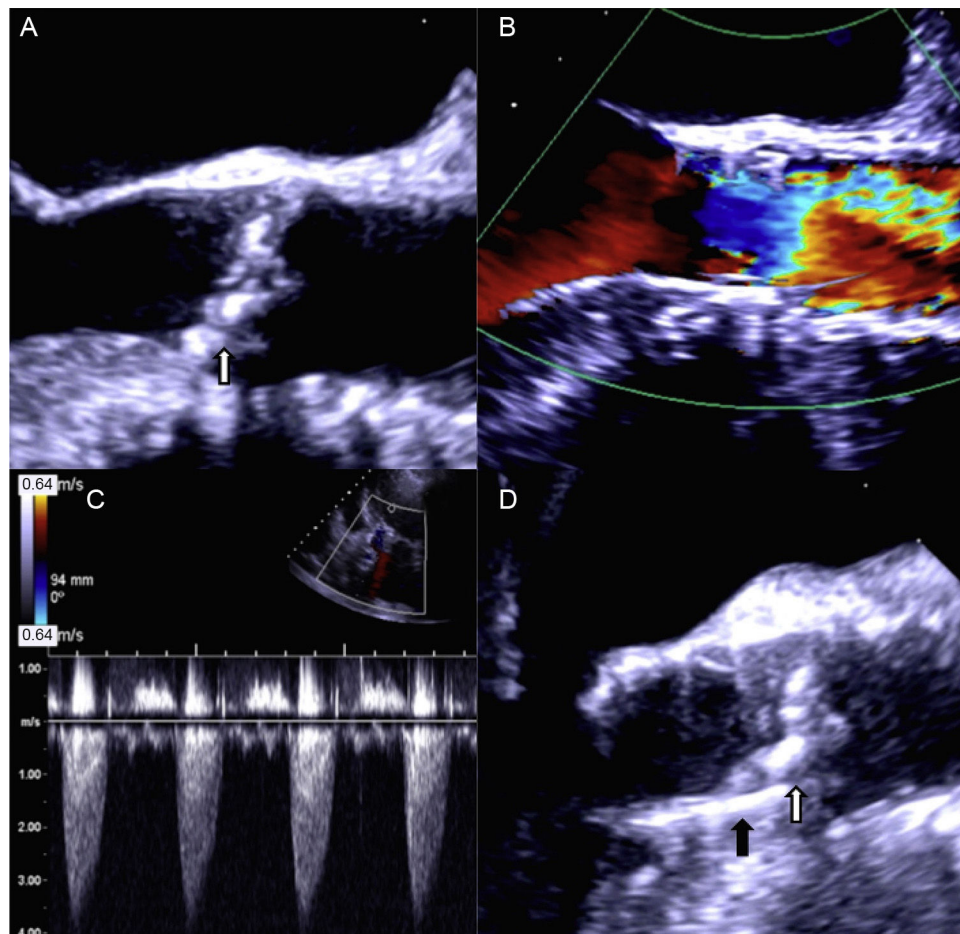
A, Echocardiographic images depicting preimplantation. B, Immediate postimplantation flow through prosthesis. C, Left ventricle-aorta gradient following prosthesis migration. D, Two-dimensional image of the prosthesis after migration. White arrow pointing toward native valve calcium. Black arrow pointing toward prosthesis.
